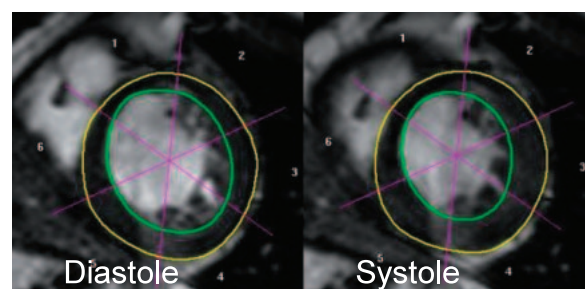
Cross sectional view for preoperative diagnostic evaluation of the patient's ventricular shape at the mitral cord—papillary muscle position; the inside (endocardial) or outside (epicardial) lines were defined by surgeons for the evaluation of ejection fraction in MRI workstation.
